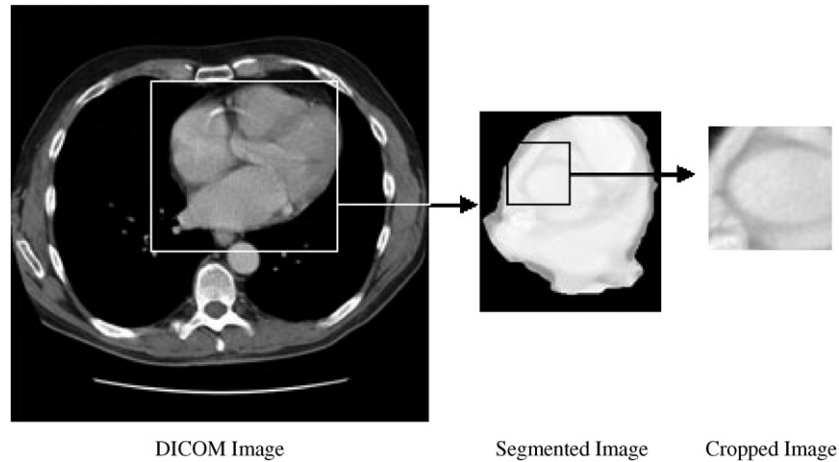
Sample from CT scan and cropped image from the data set.
